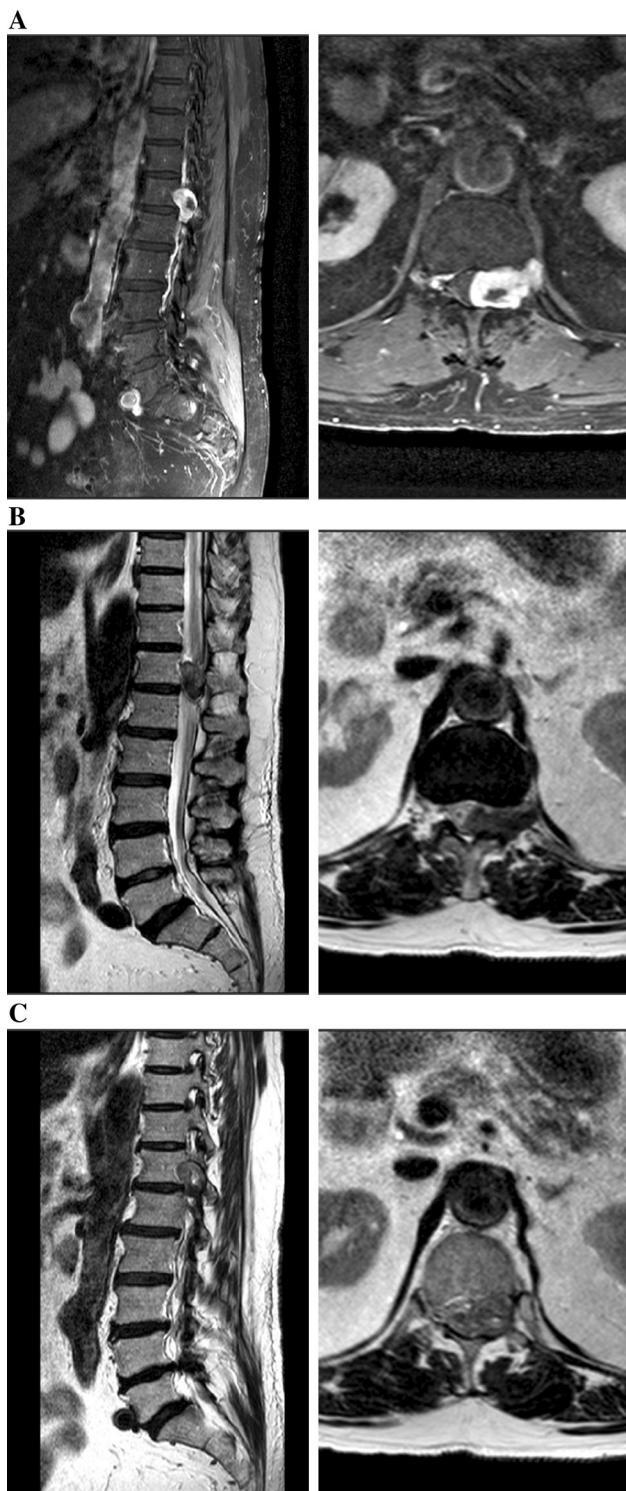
Preoperative MRI: a T1-weighted FAT-SAT axial and sagittal views showing a hyperintense lesion with heterogeneous enhancement in the left T12-L1 foramen, b T2-weighted axial and sagittal views and c T2-weighted axial and parasagittal views through the invaded foramen
